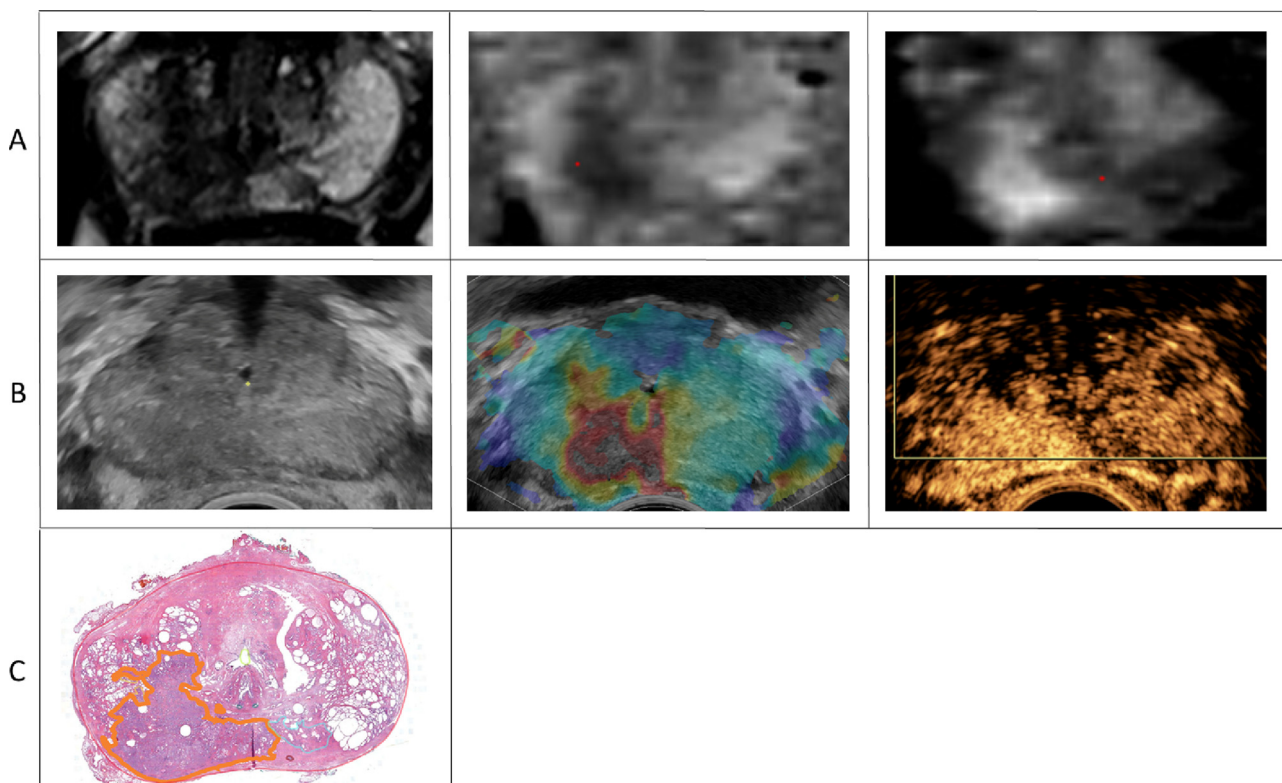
Example of a significant prostate cancer lesion visible on both MRI and mpUS. (A) Biparametric MRI sequences from left to right: T2 weighted, ADC, and DWI. PI-RADS 5 lesion in the right peripheral zone, $22 \times 11 \times 10$ mm³. Minimal ADC value of 634. (B) Multiparametric ultrasound images, from left to right: B-mode, SWE and CEUS. Right peripheral zone shows hypoechoic lesion on B-mode and correlates with an area of increased tissue stiffness on SWE and early enhancement on CEUS. (C) Whole-mount pathology shows a Gleason Score of 4 + 3 = 7 with >80% Gleason pattern 4 (annotated in orange). Lesion location corresponds to both MRI and mpUS lesions. ADC = apparent diffusion coefficient; B-mode = brightness mode; CEUS = contrast-enhanced ultrasound; DWI = diffusion weighted imaging; mpUS = multiparametric ultrasound; MRI = magnetic resonance imaging; PI-RADS = Prostate Imaging Reporting and Data System; SWE = shear-wave elastography.
